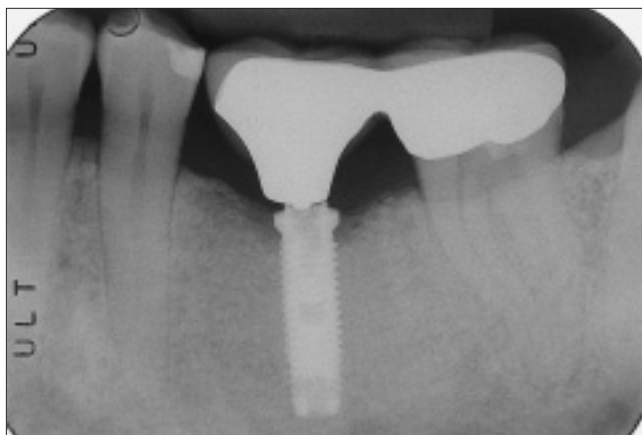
Periapical radiograph of splinted tissue-integrated prosthesis to tooth 37 with a ceramo-metal retainer.
